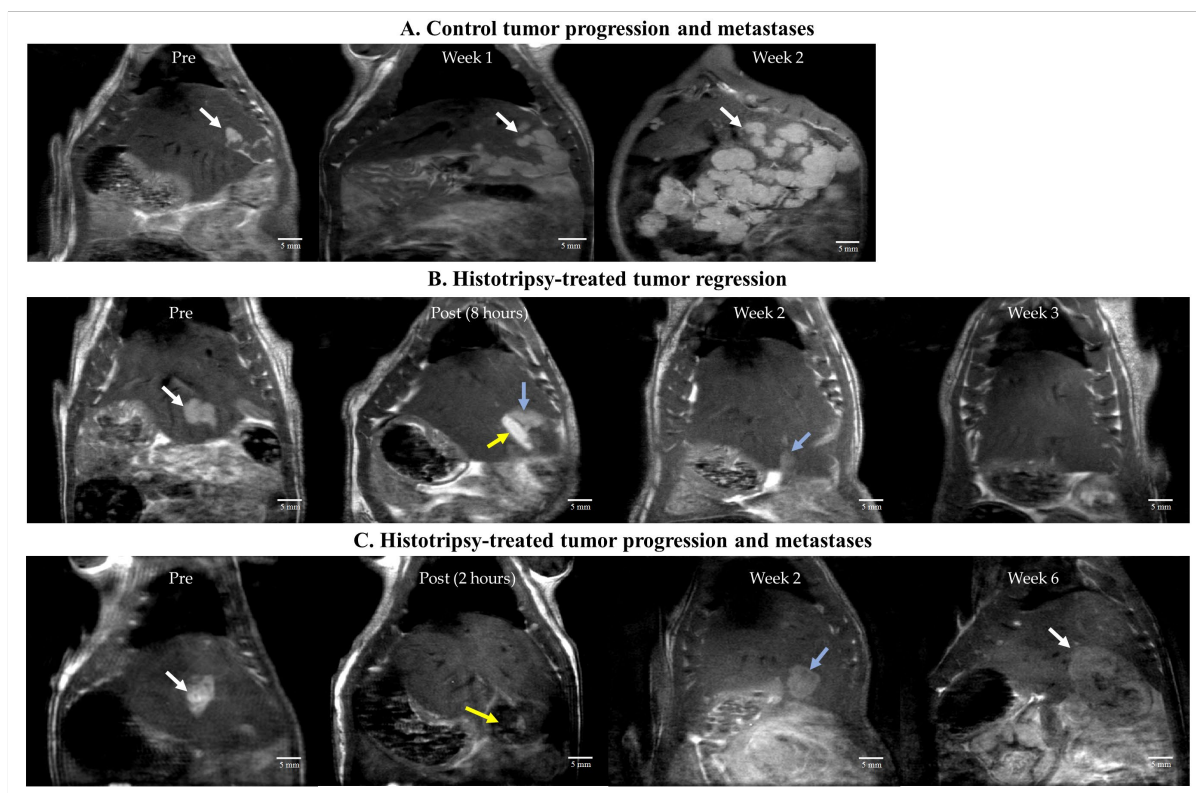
Representative T2- weighted MR images for (A) untreated control, (B) histotripsy-treated tumor showing complete regression, and (C) histotripsy-treated tumor with local tumor progression. (A) Untreated control tumor appeared hyperintense compared to surrounding liver parenchyma at pre-treatment timepoint, developed metastases at week 1 which grew aggressively by week 2. White arrows show the tumor location. (B) Post-ablation, the ablated region appears hyperintense (yellow arrow) compared to untargeted tumor (blue arrow) likely due to edema (image acquired 8 hours post treatment). By week 2, tumor appeared to regress (blue arrow) and was undetectable week 3 onwards. (C) Post-ablation, the ablated region (yellow arrow) appears hypointense (image acquired within 2 hours post treatment). At week 2, the tumor did not show signs of size regression (blue arrow). Local tumor progression and metastases were observed by week 6 (white arrow).
